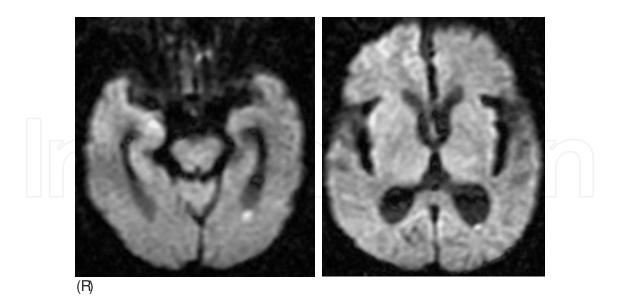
An 88-year-old man with herpes simplex encephalitis. MRI DW images on 4 days after onset revealed high intensities at the right amygdala, insula, and frontal lobe.
